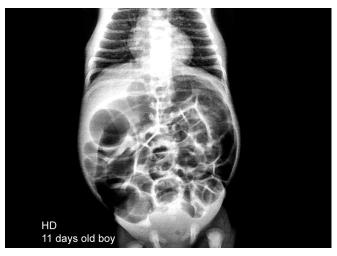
Plain X-ray in Hirschsprung disease (HD). Note peripherally dilated loops suggestive of large bowel loops. Also the pelvic gas is deficient
